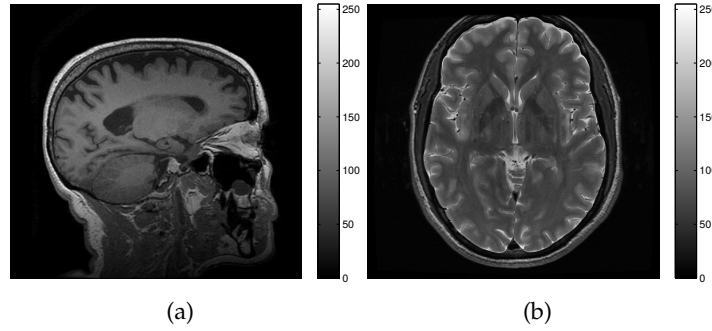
Examples of anatomical MRI. (a) is a T1 image and (b) is a T2.
